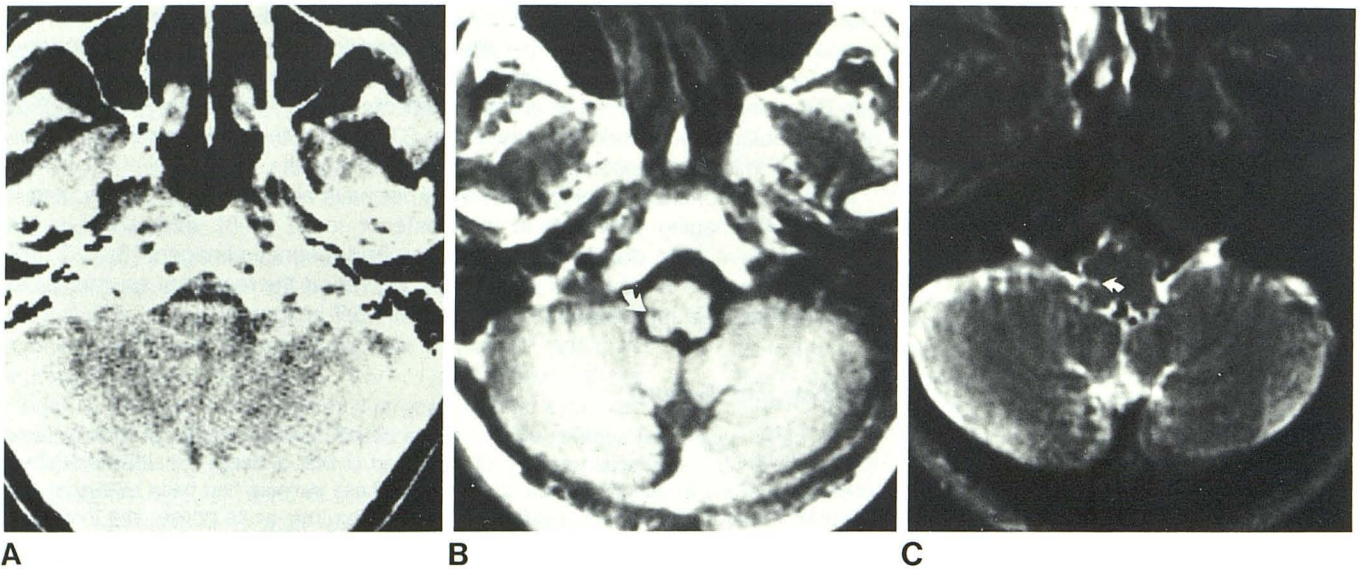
64-year-old woman who had good recovery from right lateral medulla infarction 14 months earlier. A, Unenhanced CT scan. Beam-hardening artifacts. B, PS scan, TR 300 msec. Infarction is area suggesting prolonged T1
